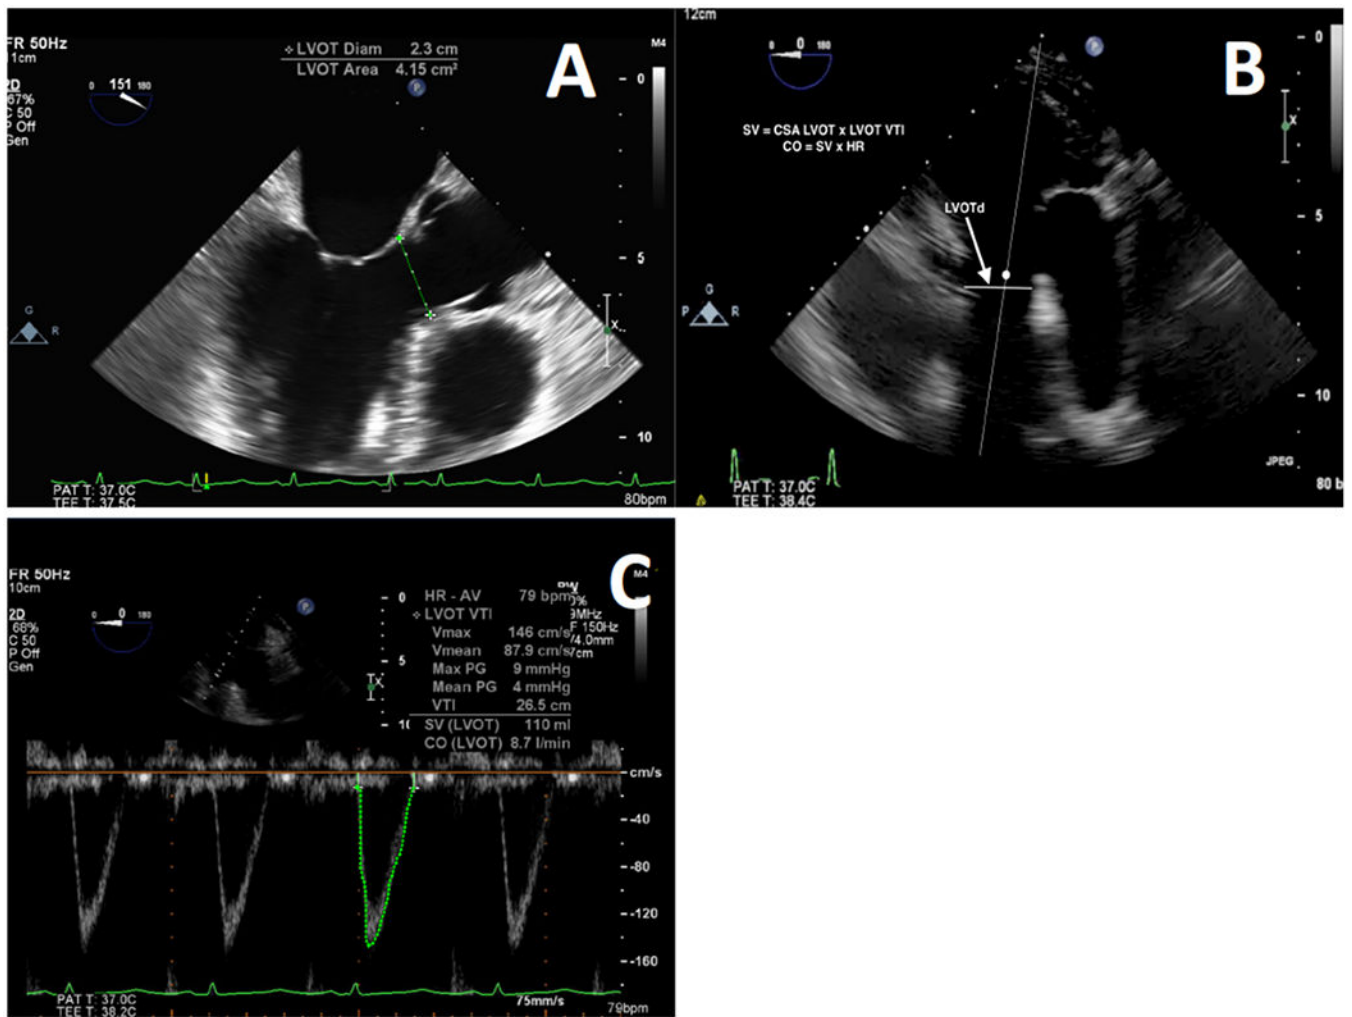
Transesophageal echocardiography (TEE) estimation of left-sided cardiac output utilizing pulsed wave (PW) Doppler of the left ventricular outflow tract (LVOT) and LVOT diameter (LVOTd). Left ventricular outflow tract diameter is best measured at the mid-esophageal long-axis view just adjacent to the aortic annulus during systole (A). The deep transgastric (TG) view is then obtained, and the PW cursor is positioned in the LVOT close to the aortic valve (AV) leaflets (B). The velocity time integral (VTI) is traced and the stroke volume (SV) is obtained (C). Heart rate (HR) is shown and cardiac output (CO) is calculated
